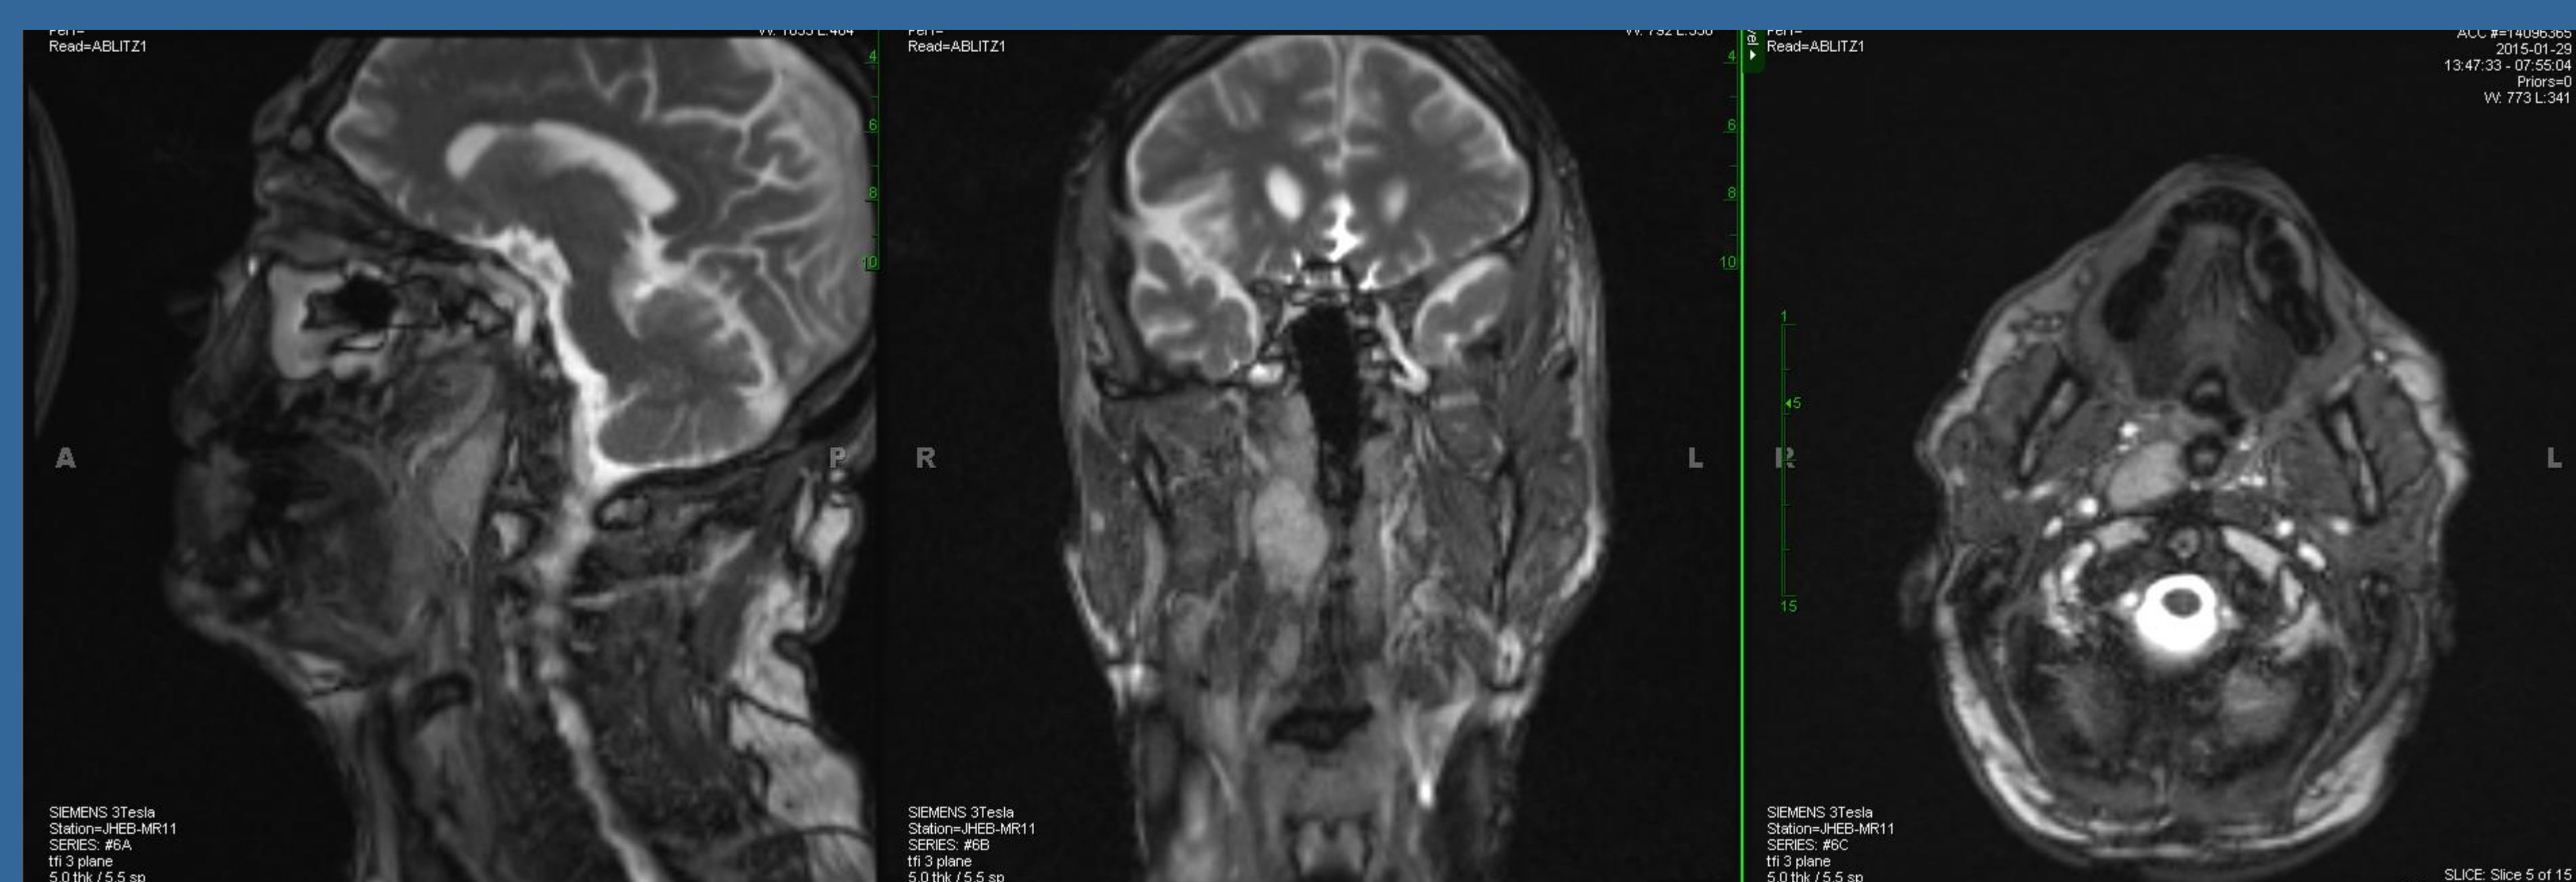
MRI demonstrating T2 hyperintense enhancing mass along the anterior aspect of right longus colli muscle
